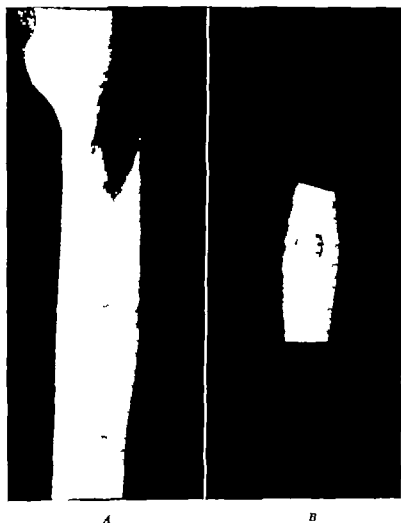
A* Roentgenogram of an osteoid-osteoma nidus developing within the cortex of the shaft of a femur. The lesion though comparatively small, has provoked considerable perifocal cortical thickening. *B* Roentgenogram of the surgically excised cortical block incorporating the lesion. The latter is relatively radiopaque and the thin lucent halo around it marks its junction with the surrounding thickened cortex.
